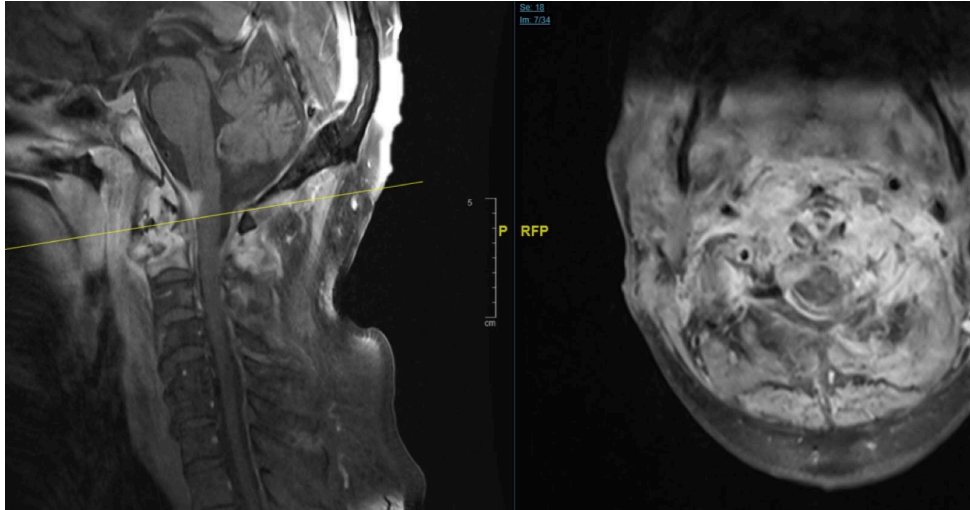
MRI revealed mild cord compression, aggressive, and destructive lesion predominately involving the body of C2, odontoid process, anterior and posterior arch of the C1 vertebra.
